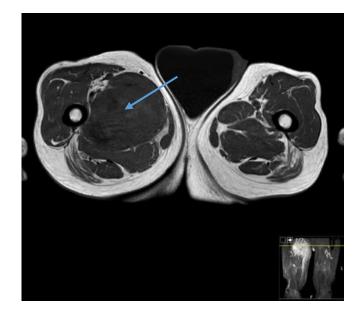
Magnetic resonance imaging (T2-weighted, transverse plane) of a patient with undifferentiated pleomorphic sarcoma (arrow) in the thigh. Image adapted from Zhang, Biomolecules, 2022.
